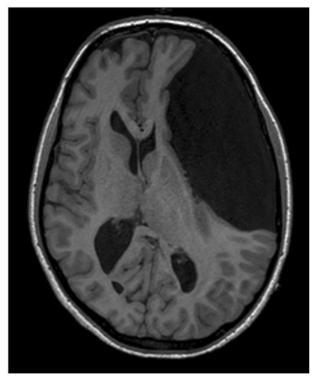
Pre-operative MRI showing a large arachnoid cyst in the left hemisphere with mass effect and compression of the ventricular system.
